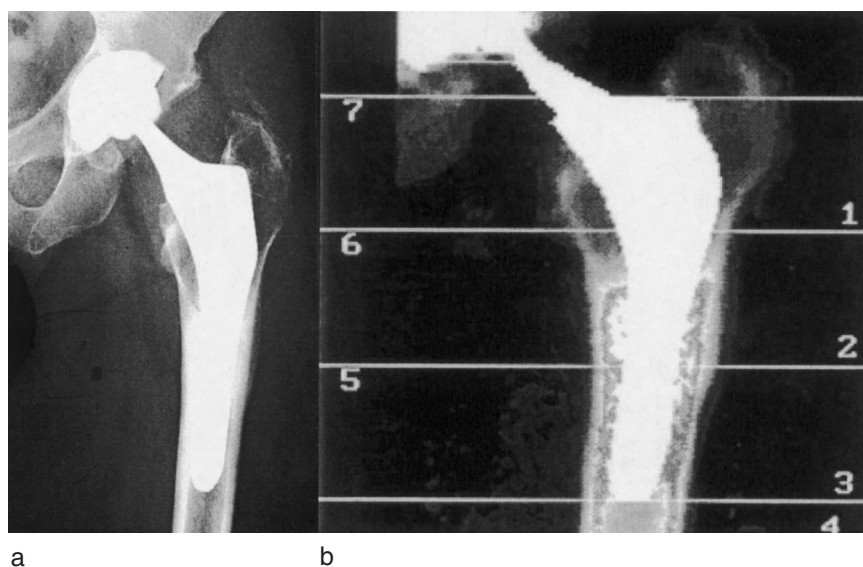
A: Postoperative X-rays of the left hip joint in the anterior/ posterior (a/p); plane after implantation of an ABG prosthesis (Stryker) using the Bauer approach. B: DEXA scan of the ABG total hip prosthesis shown in figure 1 with diaphyseal load transfer.
